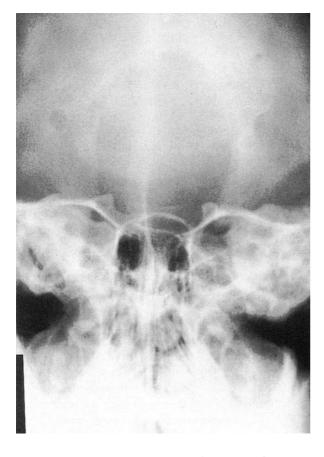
X-ray, 12 months postoperative. Same patient as Fig. 9. Almost complete disappearance of "radiolucencies".
